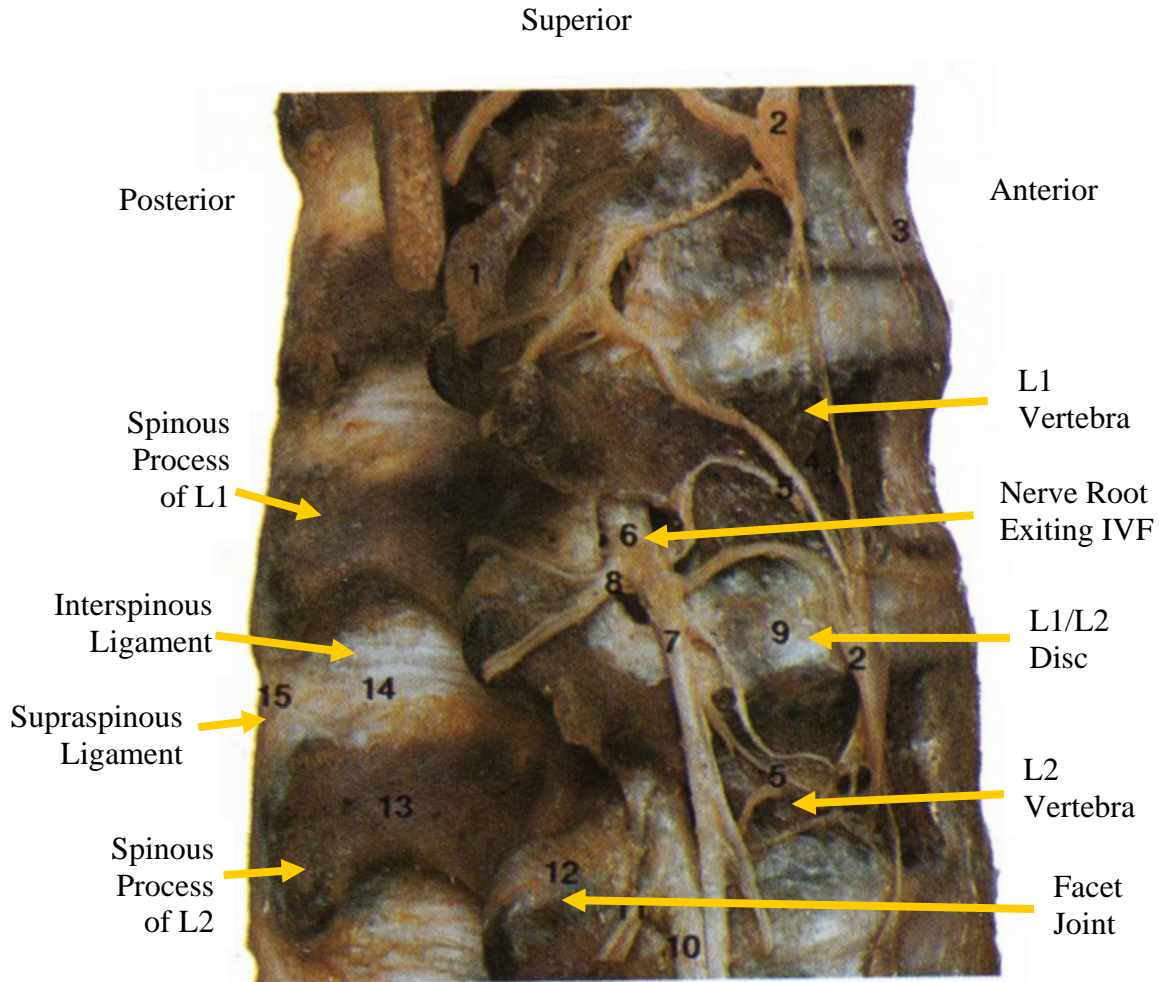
THE VERTEBRAL COLUMN IN THE UPPER LUMBAR REGION, FROM THE RIGHT SIDE, SHOWING THE LUMBAR NERVES EXITING THROUGH THE INTERVERTEBRAL FORAMINA (IVF) AND INNERVATING THE FACET JOINT AND INTERVERTBRAL DISC. NOTE: L1 AND L2 REFER TO THE 1ST AND 2ND LUMBAR VERTEBRAE RESPECTIVELY. (MODIFIED FROM McMINN, R.M.H., AND HUTCHINGS, R.T., 1989. COLOR ATLAS OF HUMAN ANATOMY. 2ND EDITION, YEAR BOOK MEDICAL PUBLISHERS, INC., CHICAGO, PP. 85.)
